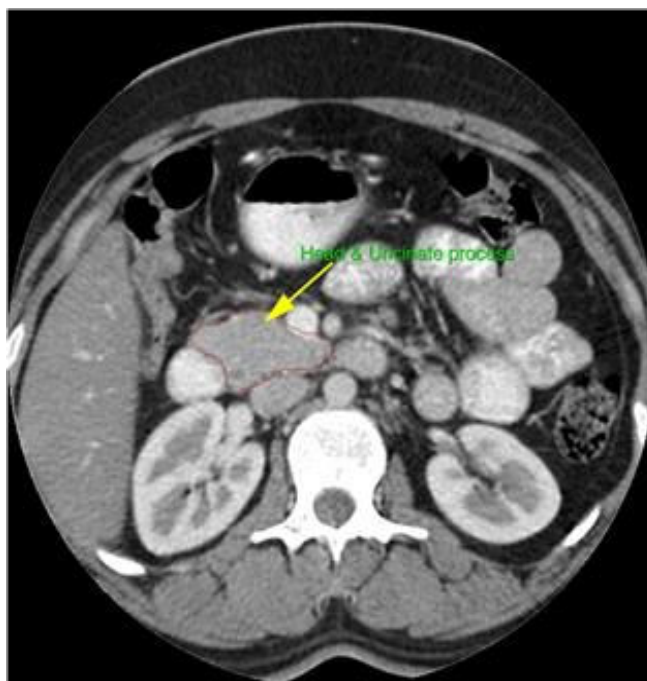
Contrast CT image of abdomen showing dorsal pancreatic agenesis, head and uncinate process seen.
